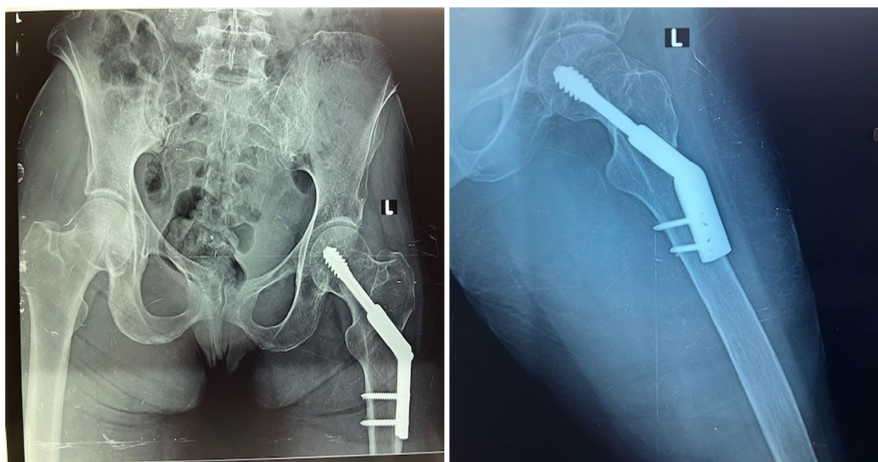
Radiographic assessment following fracture union.
